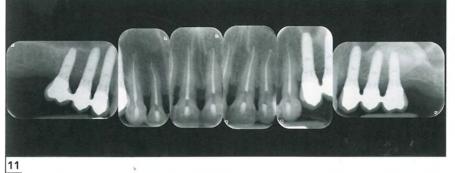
Initial radiograph revealing preexisting endodontically treated anterior teeth with periodontal bone loss and posterior implant restorations.
